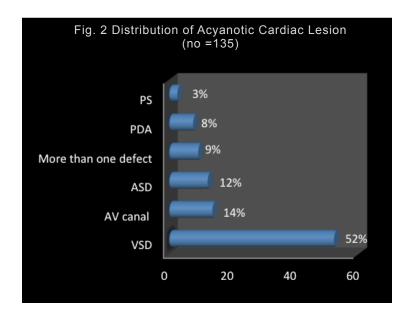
Distribution of 135 cases with acyanotic cardiac lesion based on echocardiography. (PS Pulmonary stenosis, PDA patent ductus arteriosis, ASD atrial septal defect, VSD ventricular septal defect, AV atrieoventricular).
